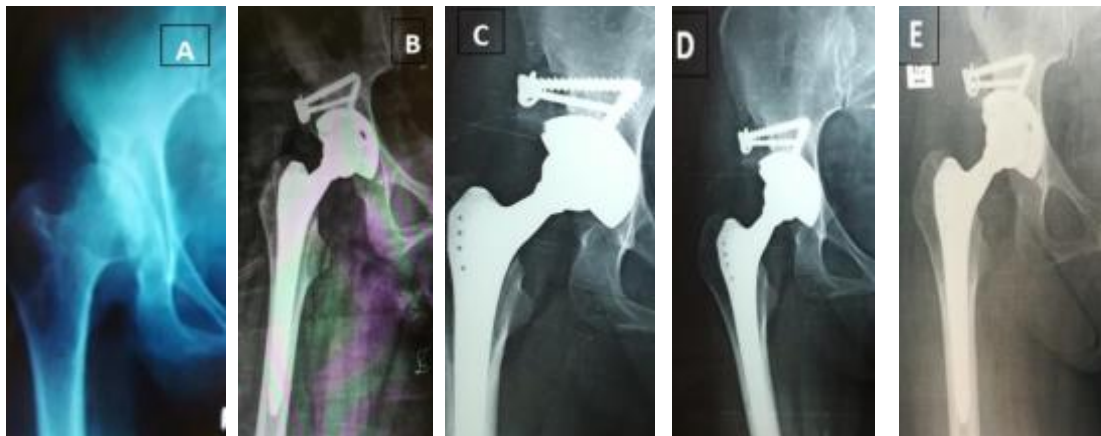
Female case, 43 years old with left acetabular dysplasia, (A) Preoperative x-ray, (B) Immediate postoperative x-ray, (C) Radiological follow up after 2 weeks, (D) after 3 months and (E) after a year.
